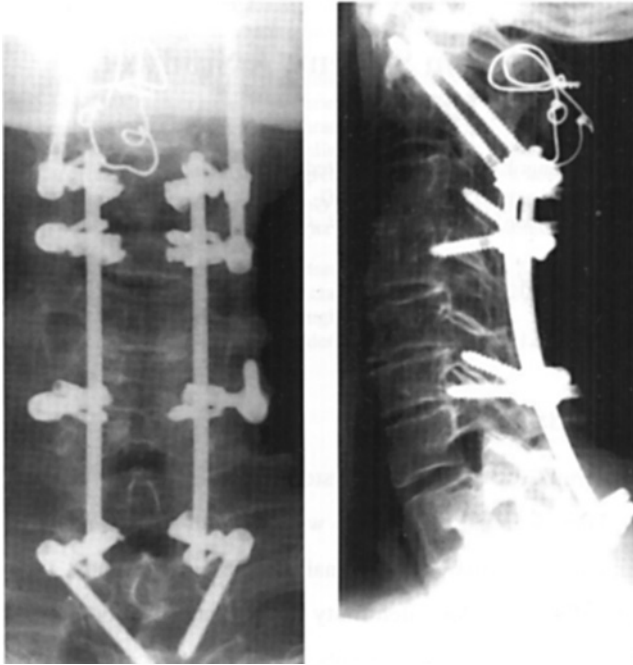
The system allows different screw positioning techniques to be used in the same construct. This 76 year old man (patient #1) with rheumatoid arthritis and a previous C1-C2 fusion developed subaxial subluxation with mainly local pain. He was fused from C1 to Th1 with transarticular screws in C1-C2, pedicular screws in Th1, and lateral mass screws on the left side and subaxial transarticular screws on the right side in the lower cervical spine. The one-year follow-up radiographs show solid fusion in good alignment.
